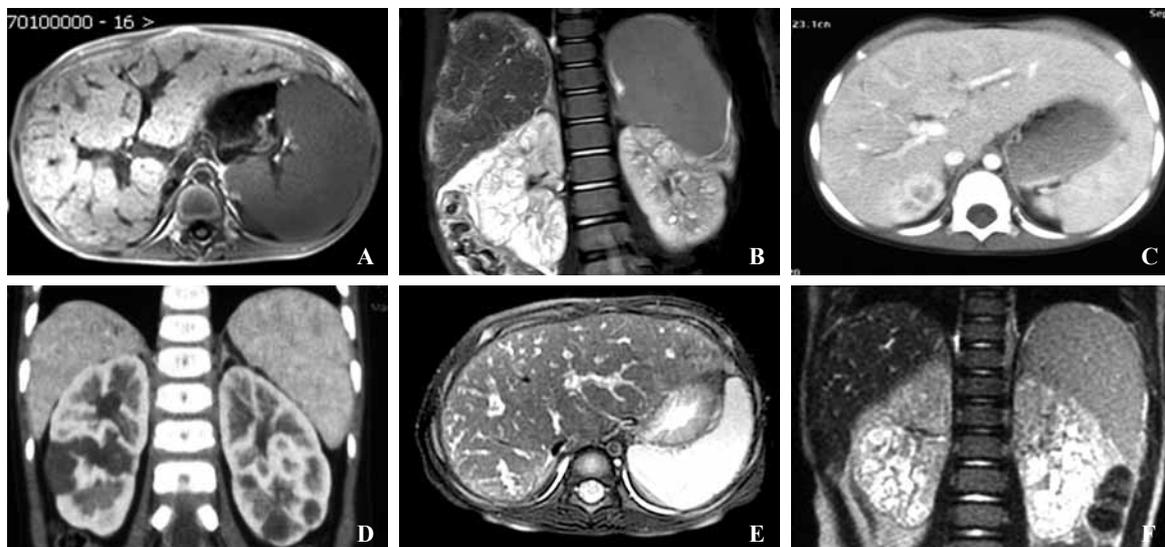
Abdominal MRI and CT images of the three children. A&B: Axial and coronal T1- and T2-weighted MRI images of Patient 1 showing enlarged kidneys, multiple tiny bilateral kidney cysts, intrahepatic bile duct dilatation and hepatosplenomegaly; C&D: Axial and coronal enhanced CT images of Patient 2 showing enlarged kidneys, multiple renal cysts and intrahepatic bile duct dilatation; E&F: Axial and coronal T2-weighted MRI images of Patient 3 showing enlarged kidneys, multiple bilateral kidney cysts, intrahepatic bile duct dilatation and hepatosplenomegaly.
